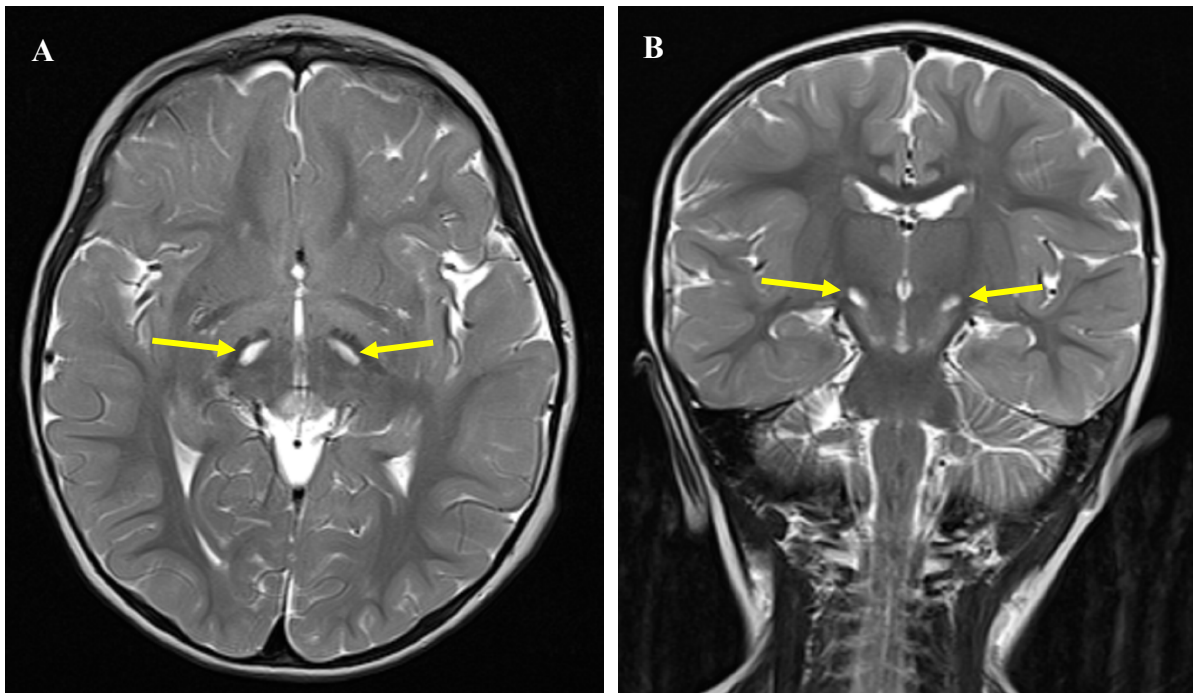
Brain MRI radiological images of Patient 8
